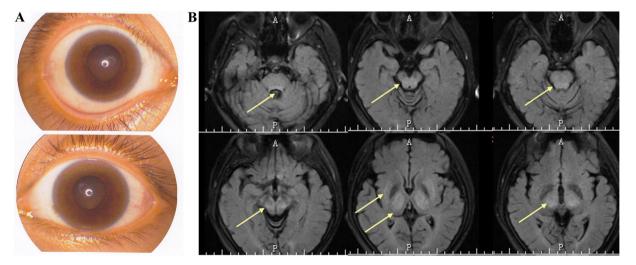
K–F rings and abnormal MRI of the Wilson's disease patient (WD001). A. The results of slit lamp eye examination revealed the Kayser–Fleischer (K–F) rings, rusty brown ring around the cornea of the eyes, because of the deposition of copper in descemet's membrane in the patient (WD001). B. Brain Magnetic Resonance axial FLAIR image displaying symmetrical high signal intensity changes in the tectum of midbrain, tegmentum of pons, thalamus and lentiform nuclei (arrow head) in the Wilson's disease patient (WD001).
